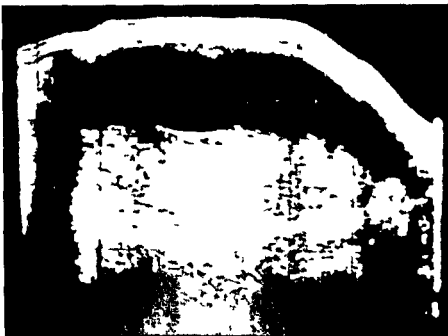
Ultrasound plamography demonstrating a very thick posterior placenta. Maximal thickness 8 cm. Midline longitudinal section
